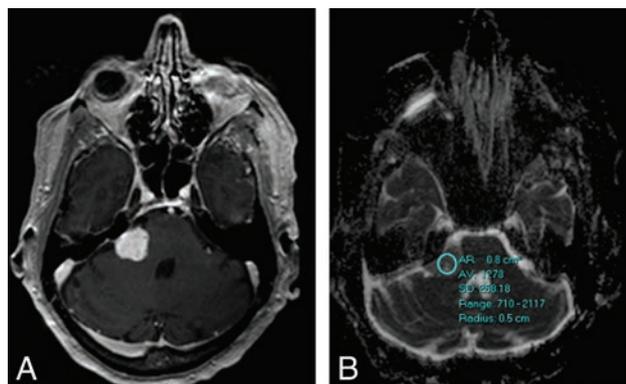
A, Postcontrast T1-weighted axial scan through the posterior fossa shows a right cerebellopontine angle vestibular schwannoma. B, The ADC values were calculated from an elliptical region of interest.
